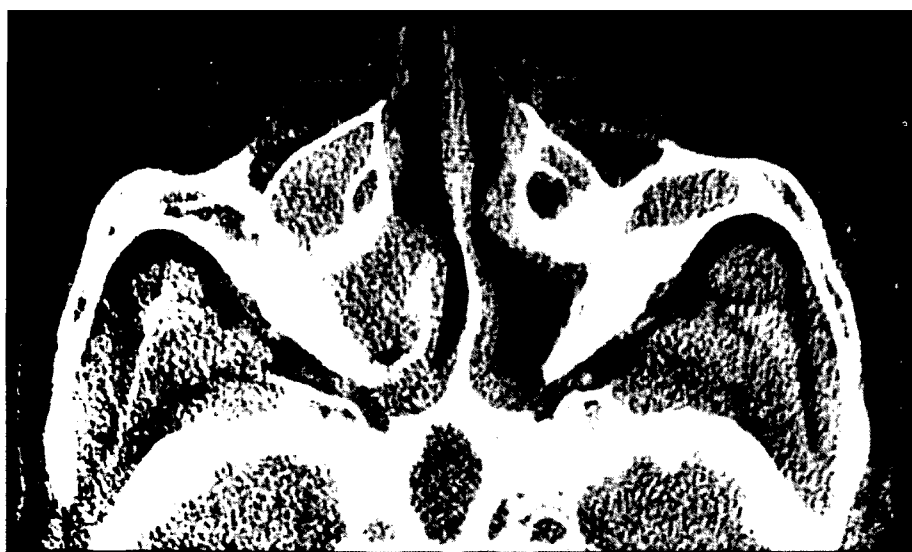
Axial projection of CT scan shows generalized soft tissue shadow in the right maxillary sinus. Postoperative maxillary cyst is observed in the left antrum.
